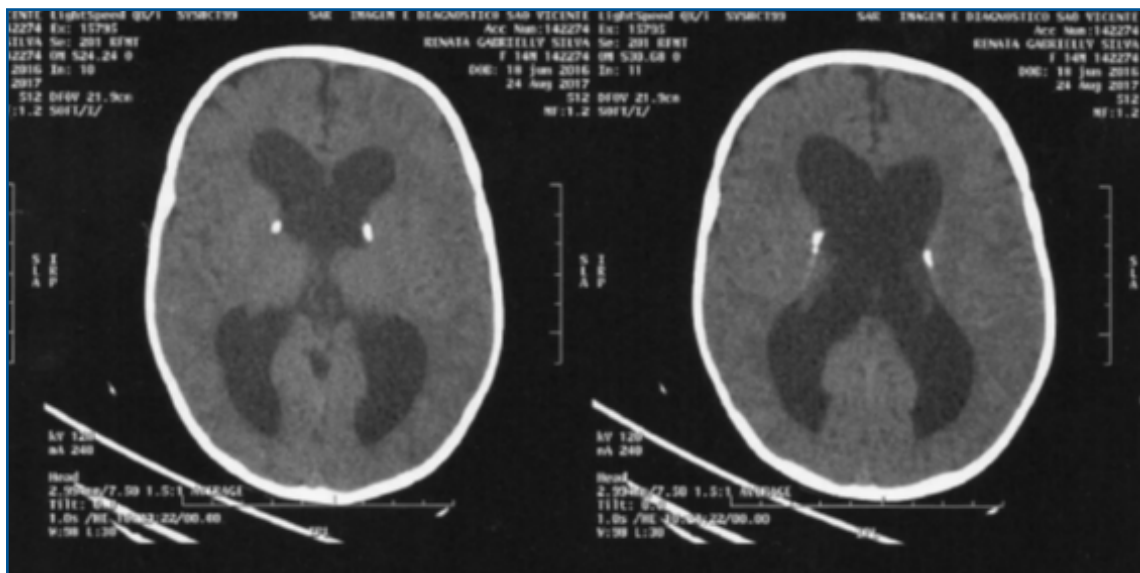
Axial computed tomography of the skull (Twin 1)
